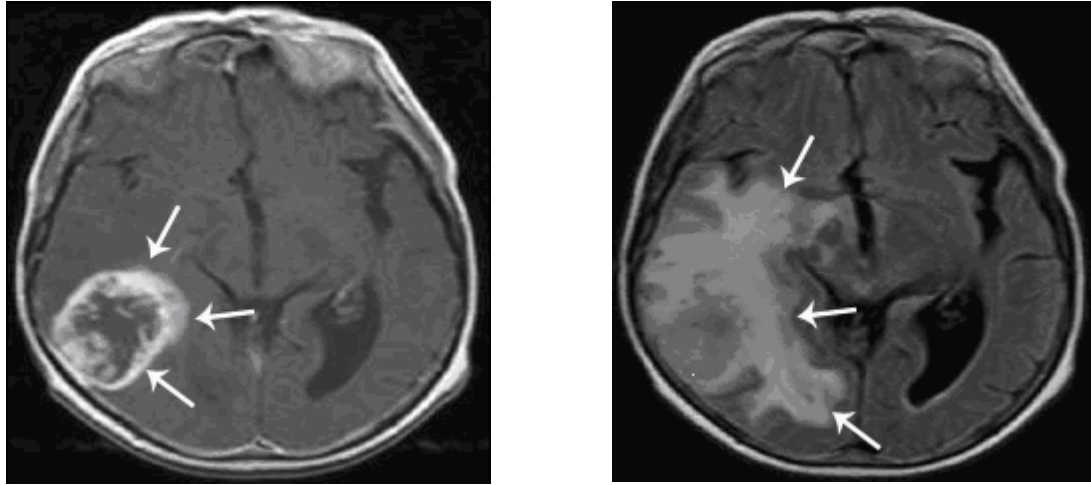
Sample MR images of tumor used in the study
